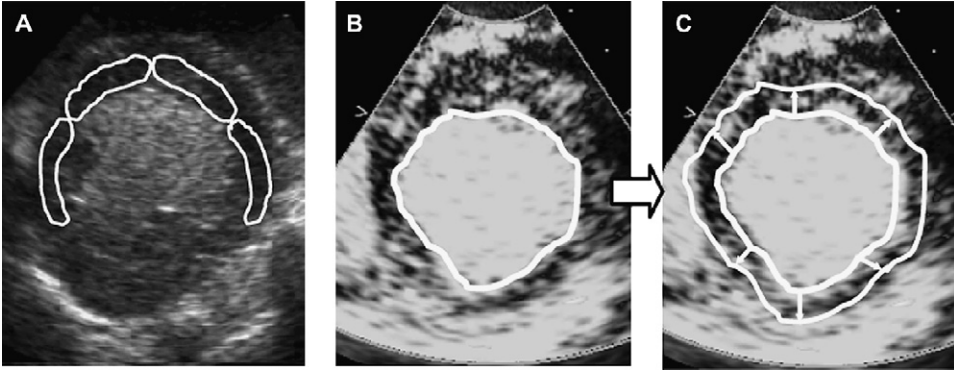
Regional contrast is usually assessed by manually tracing myocardial regions of interest (A). High-contrast LV cavity is suitable for automated endocardial border detection (B), which allows automated identification of the myocardium (C) in each consecutive end-systolic frame, as a basis for automated, translation-free perfusion analysis. (Reproduced from Caiani EG, Lang RM, Caslini S, et al. Quantification of regional myocardial perfusion using semiautomated translation-free analysis of contrast-enhanced power modulation images. *J Am Soc Echocardiogr* 2003;16:116–123; with permission. Copyright © 2003, American Society of Echocardiography.)
